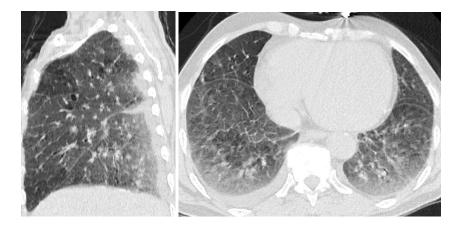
53 year-old male patient known cardiac disease complaining of cough and dyspnea. Axial and sagittal reformatted images of chest CT showing ground glass veiling (ill-defined and peripheral dependent), associated prominent smooth interlobular septations. Case of bilateral interstitial pulmonary edema.
